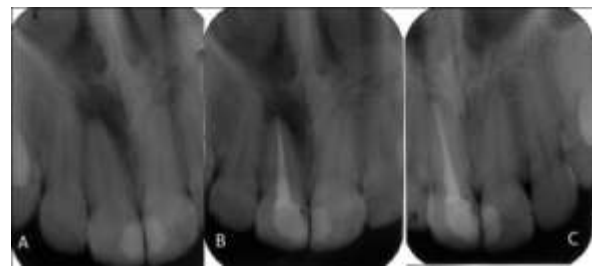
(A) Initial radiograph revealed a large periapical lesion, (B) Radiograph at the final of endodontic treatment, (C) Radiograph at one year, revealing complete repair.
